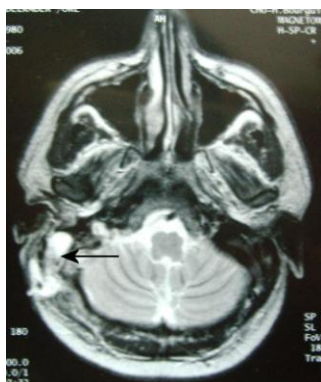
Axial T2-weighted MR image: Hyperintense thrombus at the level of the sigmoid sinus
